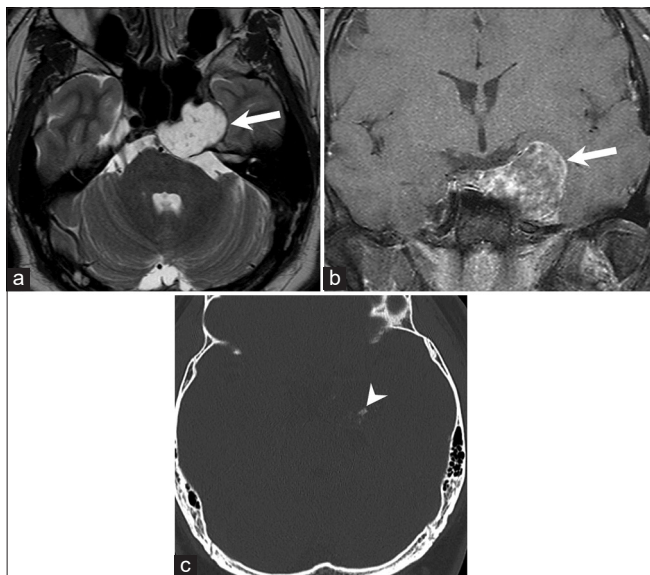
Skull base chondrosarcoma. A 31-year-old man with skull base chondrosarcoma presenting with progressive left cranial neuropathy. Axial T2W MRI image (a) and coronal contrast-enhanced T1W MRI image with fat suppression (b) show a large expansile heterogeneously enhancing T2 hyperintense extraaxial mass centered at the left petroclival fissure (arrows) extending into the prepontine cistern and causing mild mass effect on the adjacent brainstem and left temporal lobe. The tumor contains subtle small calcifications (arrowhead), a clue to the diagnosis, best seen on CT (c).
